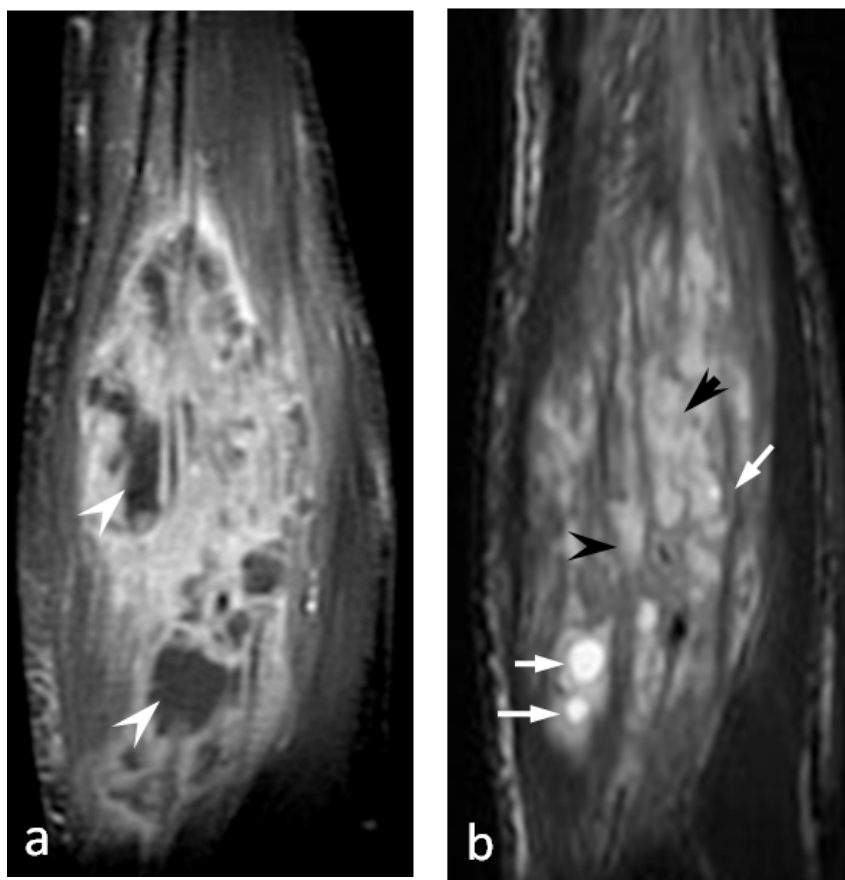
Magnetic resonance imaging. Sagittal T1 post gadolinium (a), and fat suppressed T2 (b) weighted images showing pseudotumoral lesion with daughter cysts (arrows). Note many collections into lesion (head arrows).
